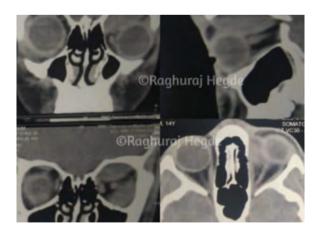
CT scan of the Orbits (Axial, Coronal and Sagittal reconstruction) showing a dome-shaped mass in the superomedial subperiosteal space.
